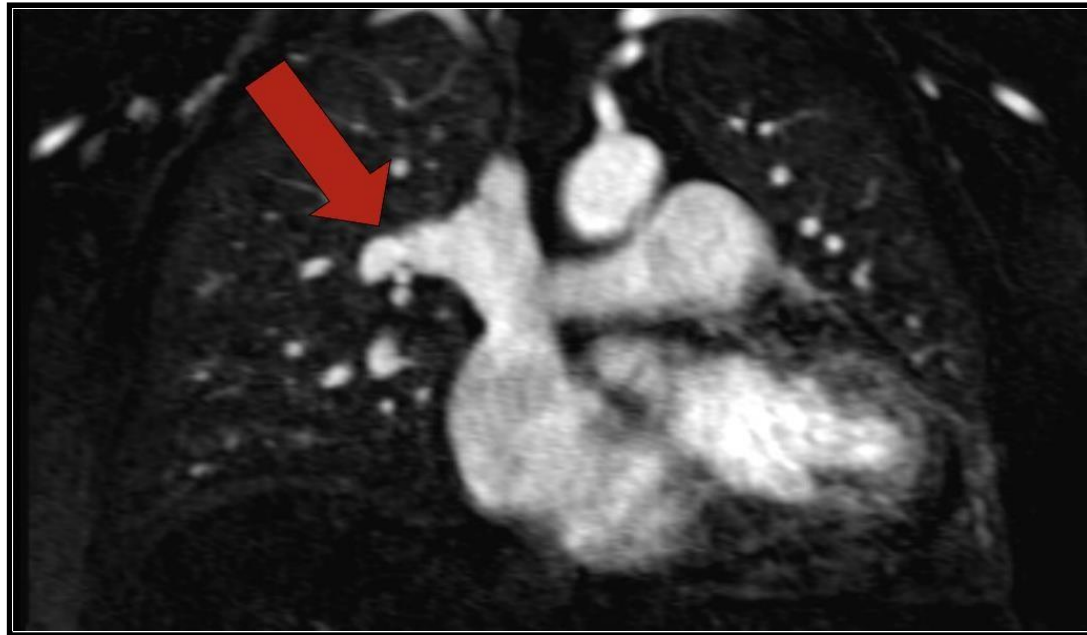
(Above, MRI coronal): Red arrow depicts aberrant right upper pulmonary vein draining into the SVC. Right sided PAPVR is more commonly diagnosed in children. PAPVR in this case-report is right sided and was not diagnosed until symptomatic onset later in adulthood. The thought is that children are more often symptomatic and will present earlier in life as a result. Also, secondary pulmonary hypertension is typically a rare complication, but was seen in this case resulting in Right Ventricular (RV) enlargement noted on MRI above, as well as the case-report symptoms (Shortness of breath, hypertension, etc.) Images courtesy of Dr. Shackles.
